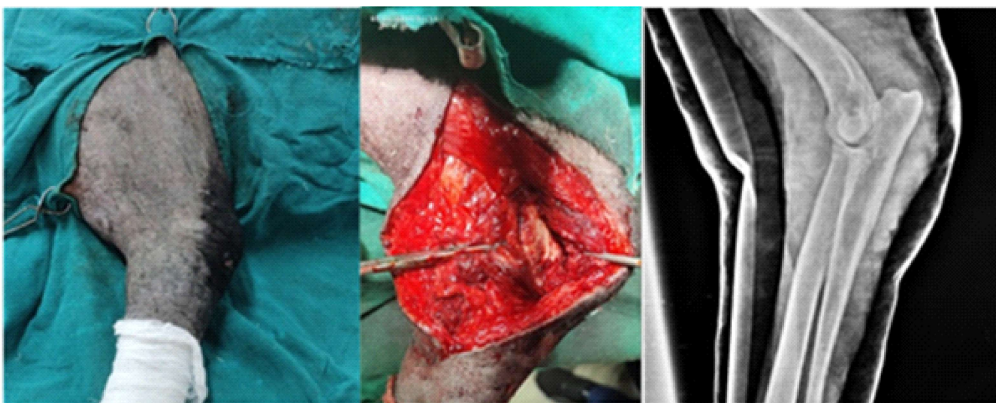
Intra-operative exposed elbow joint and immediate postoperative radiograph of the reduced and externally immobilized elbow joint
